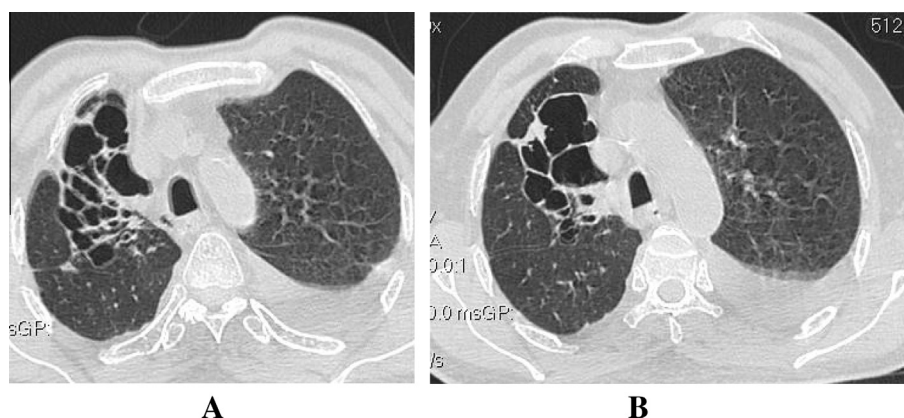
(A and B) HRCT scan showing right upper lobar anterior segment cystic bronchiectatic changes.
